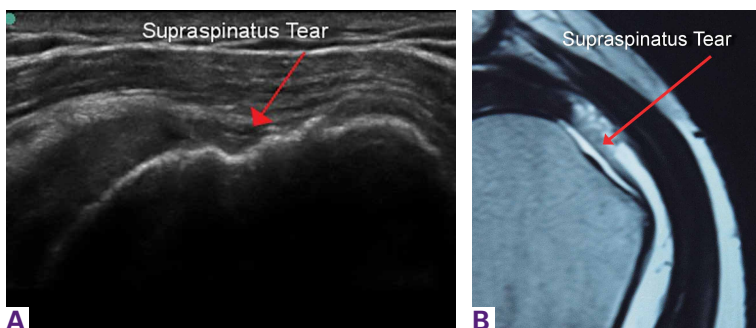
(A) Ultrasound image of left shoulder, long axis view. Torn supraspinatus tendon insertion from the greater tuberosity. Red arrow indicates tear. (B) Magnetic resonance imaging of left shoulder, coronal view. Torn supraspinatus tendon insertion from the greater tuberosity (same patient as in Figure 2A). Red arrow indicates tear.
